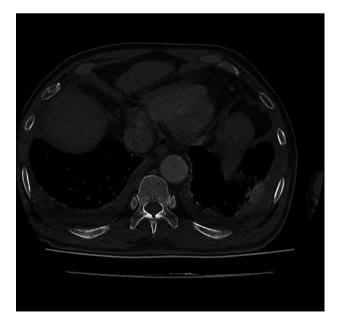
An image from the patient's thorax computed tomography. Areas marked with arrows show bilateral pleural effusion
